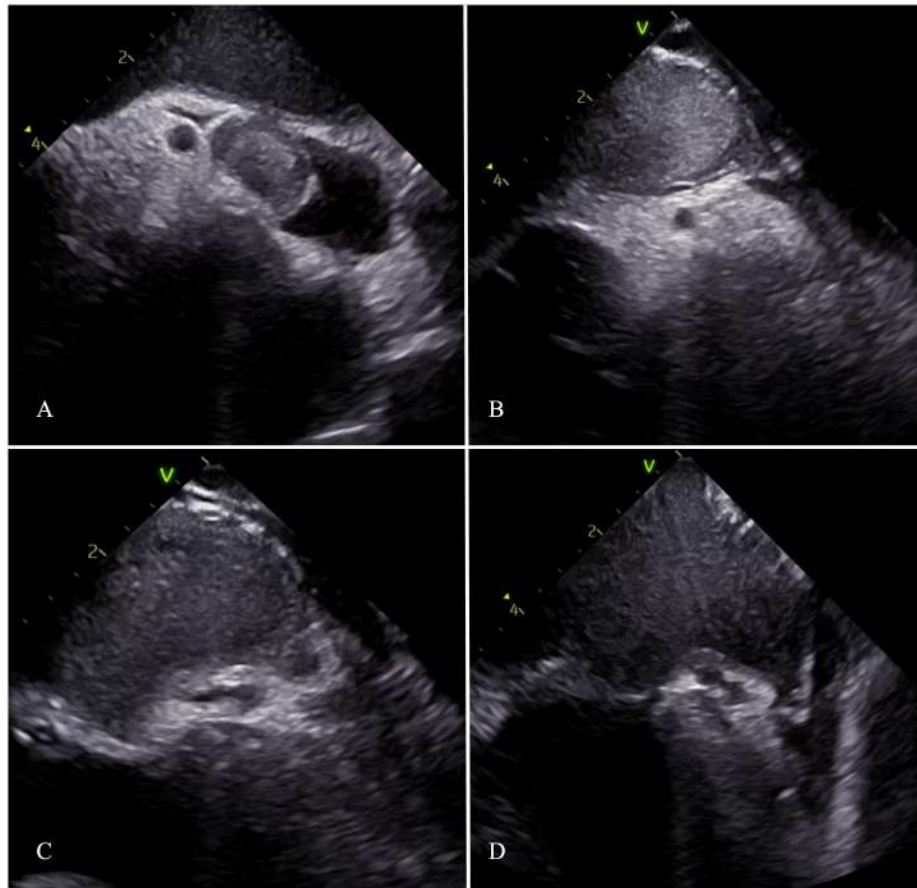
Intracardiac echocardiographic evaluation of the left atrial appendage. (A) Right atrial view demonstrating a globular echogenic structure within the left atrial appendage. (B) Left atrial view after transseptal access providing improved delineation. (C) During isoproterenol infusion, dispersion of spontaneous echo contrast is observed. (D) After isoproterenol infusion, resolution of spontaneous echo contrast.
